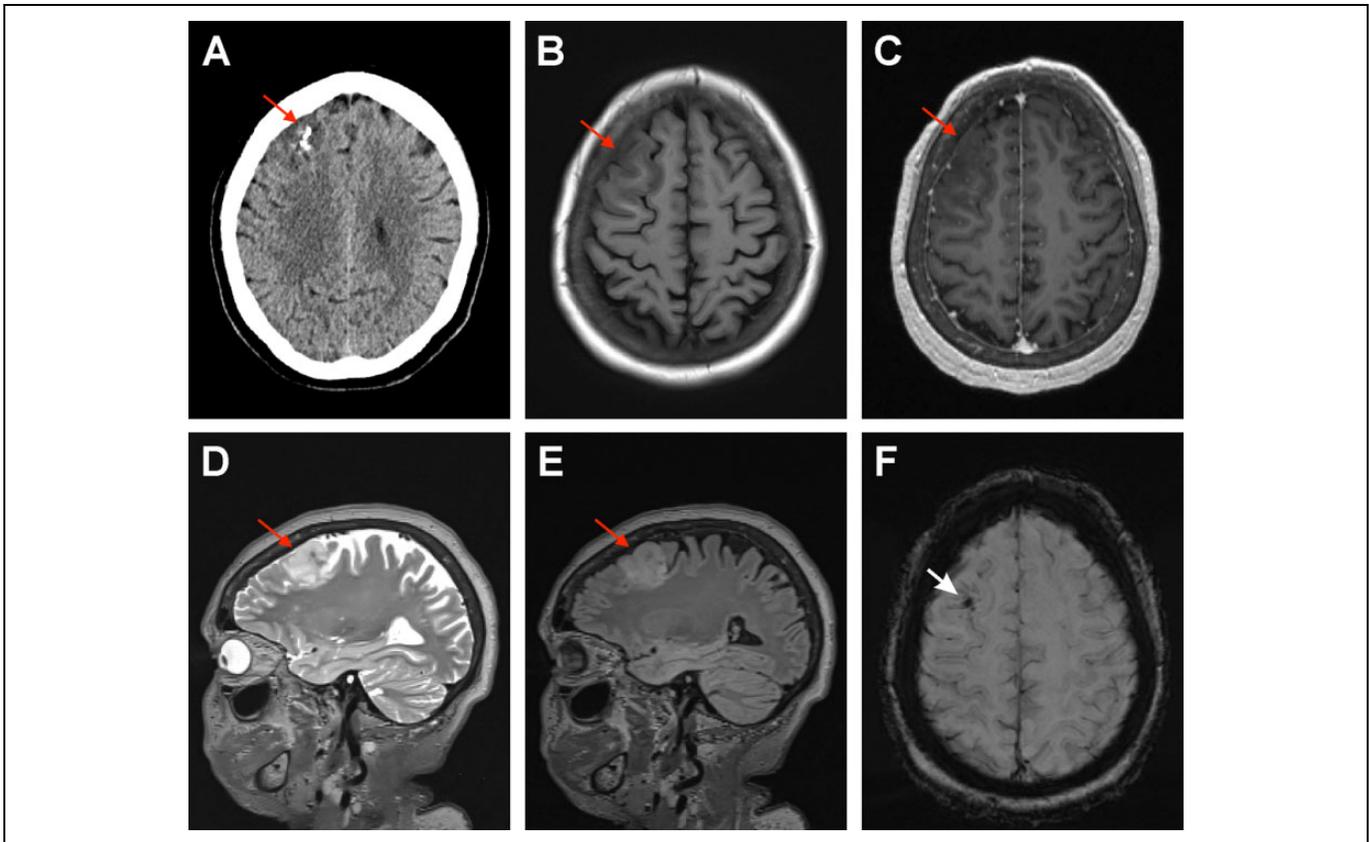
Patient 2 imaging. A, Mild expansion of gyri, blurring of gray-white boundary, and calcifications (red arrow) is observed in the right frontal cortex on axial, noncontrast computed tomography (CT). A hypointense mass (B; red arrow) that does not enhance with the addition of contrast (C; red arrow) is observed on T1-weighted magnetic resonance imaging (MRI). The mass is hyperintense on T2-weighted imaging (D; red arrow) and on fluid attenuation inversion recovery (FLAIR; E; red arrow). F, Mineral deposition, consistent with calcification, is identified on susceptibility-weighted imaging (white arrow).
